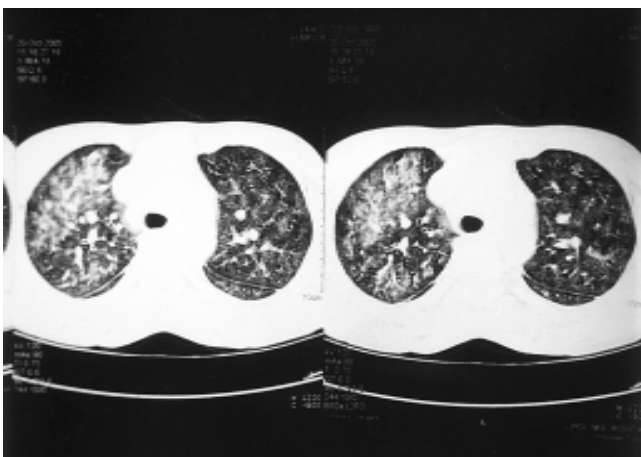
CT scan chest showing middle section
